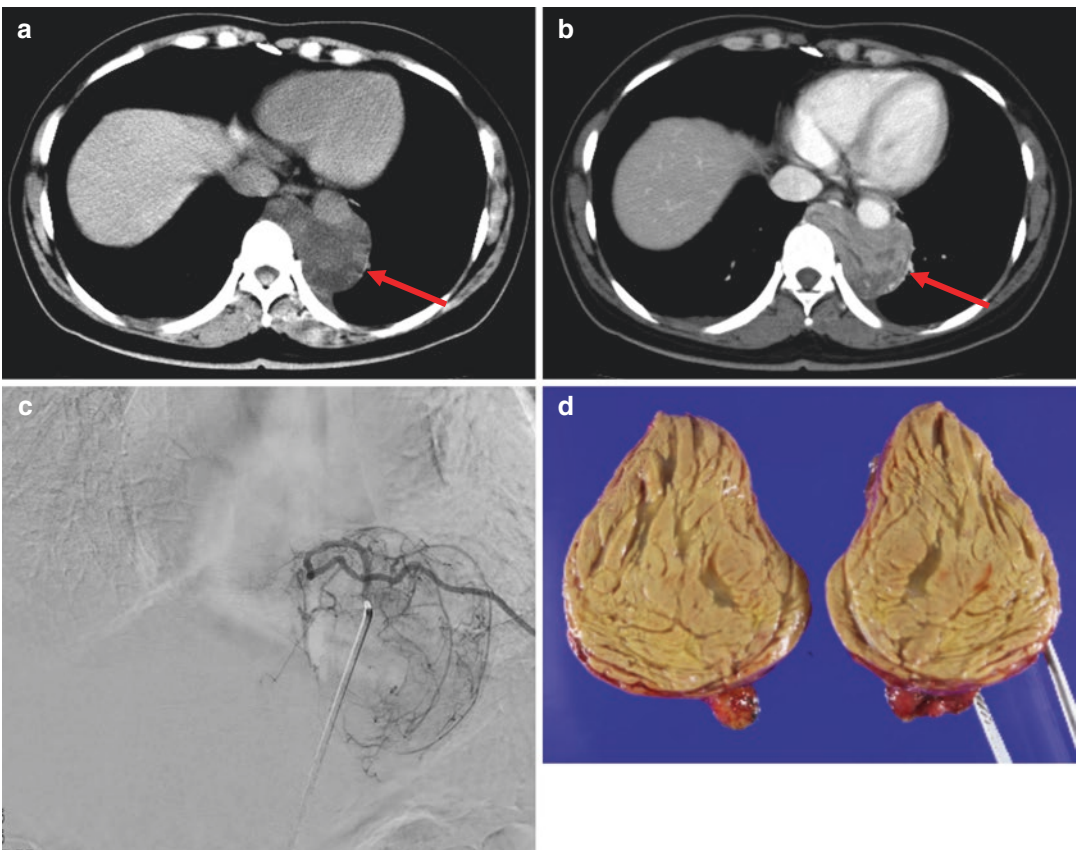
Hibernoma. Precontrast CT scan (a) shows a left posterior mediastinal mass (arrow) with heterogeneous low attenuation (mean HU 10). Postcontrast CT scan (b) shows prominent enhancement of the mass
